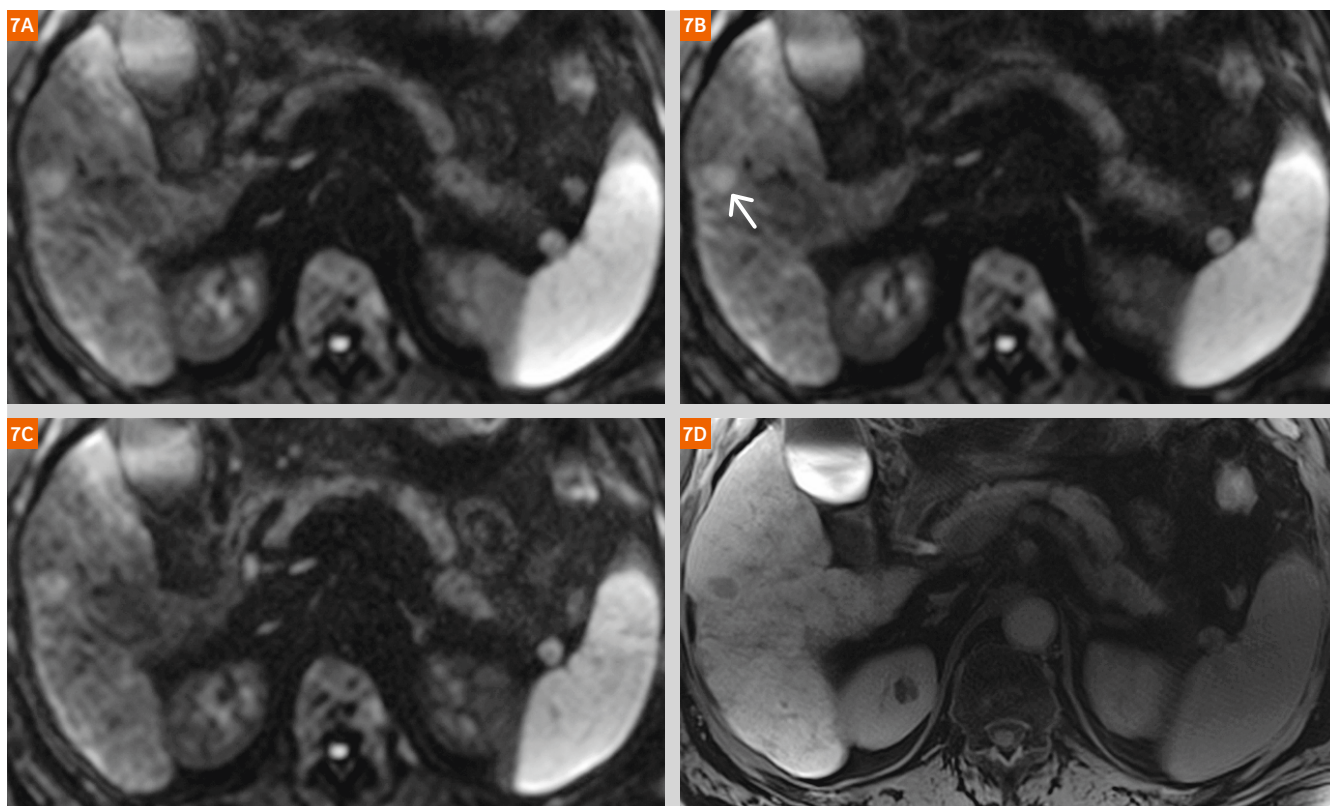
2D ss-EPI DWI SMS in the liver for shorter scan acquisition or alternatively thinner sections. DWI scan times were (7A) 2:41 min (non-SMS), (7B) 1:38 min, and (7C) 2:54 min (both SMS with a 2 fold acceleration). The slice thickness in 7A and B was equivalent (5 mm), with 7C performed using a thinner slice (3 mm), and complete liver coverage with all scans. A small HCC with restricted diffusion (arrow) is noted. The lesion is also well seen on delayed imaging after gadoxetic acid administration, in (7D) a non-breath-hold 2-minute acquisition radial VIBE scan.
